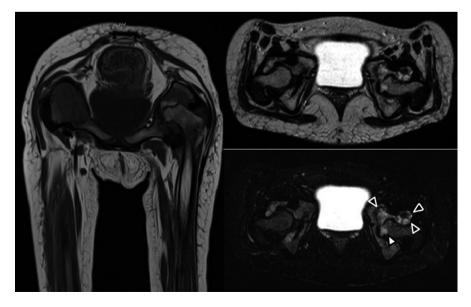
MRI of the hips: Multiple confluent hyaline masses in the joint space of the hip (black arrowhead) with erosion of the femoral head (white arrowhead)
